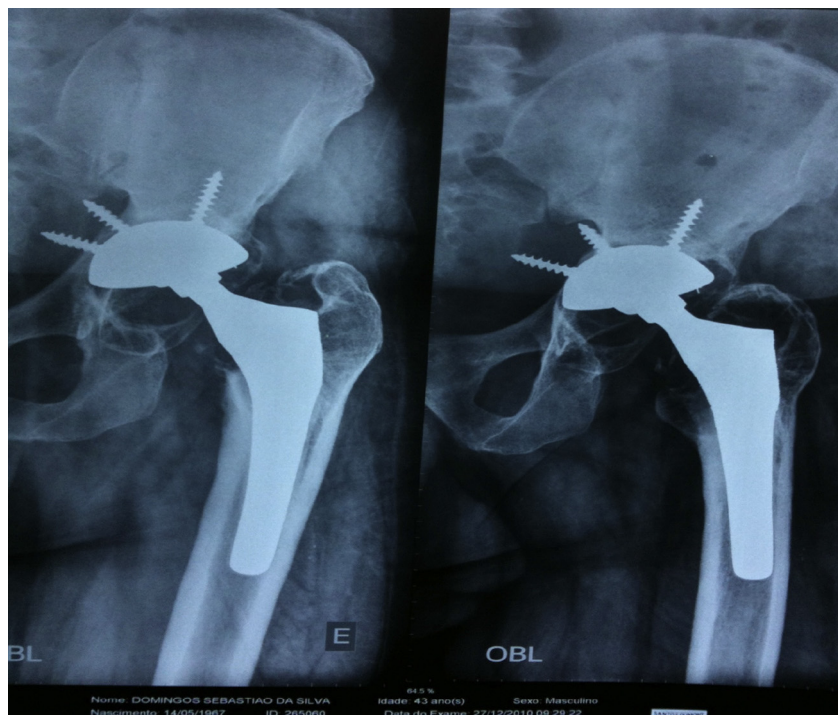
Radiographs of the left hip in anteroposterior and oblique views (December 27, 2010) showing total arthroplasty performed 17 years earlier.
